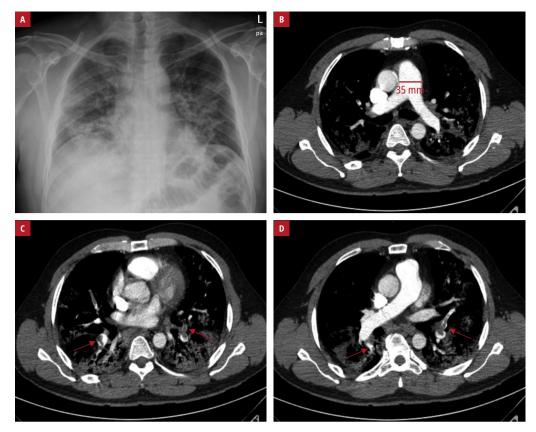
A – chest X-ray showing bilateral interstitial pneumonia; B – computed tomography angiography of the main pulmonary artery and the main branches. The main pulmonary artery is up to 35 mm in diameter, which is suggestive of significant pulmonary hypertension. C, D – computed tomography angiography demonstrating a thrombus in the bilateral segmental arteries (arrows)
